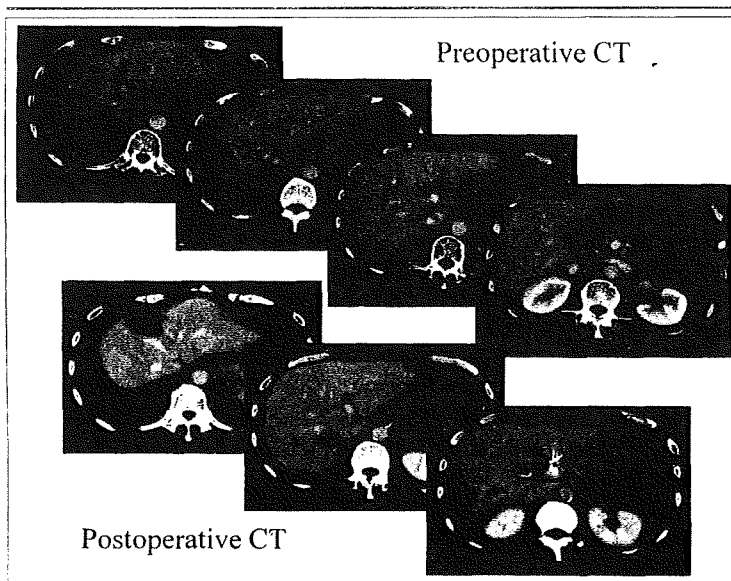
Pre- and post-operative CT scans. A 51-years old man presented rectal cancer associated with 5 synchronous liver metastases in the bilateral lobes. Low anterior resection and hepatic wedge resection of S1, S3 and S4-8 were performed, and the other 2 liver lesions in S6 and S7 were treated with RFA (arrow). Total resection of the metastatic lesions was thought to be too invasive because of the bilateral distribution, the deep location within the hepatic parenchyma, and the concomitant resection of the primary lesion.
